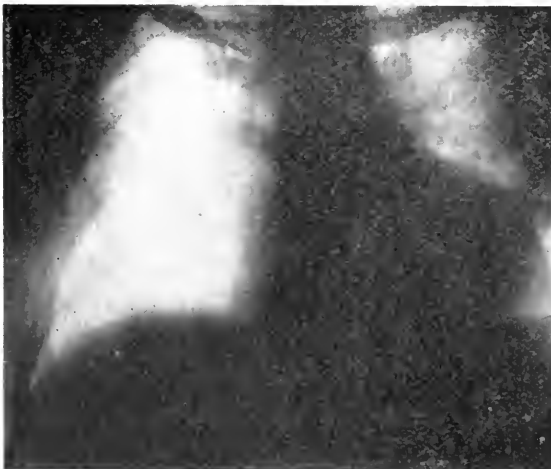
Wm. L. Roentgenogram taken March 31, 1916, on discharge.
